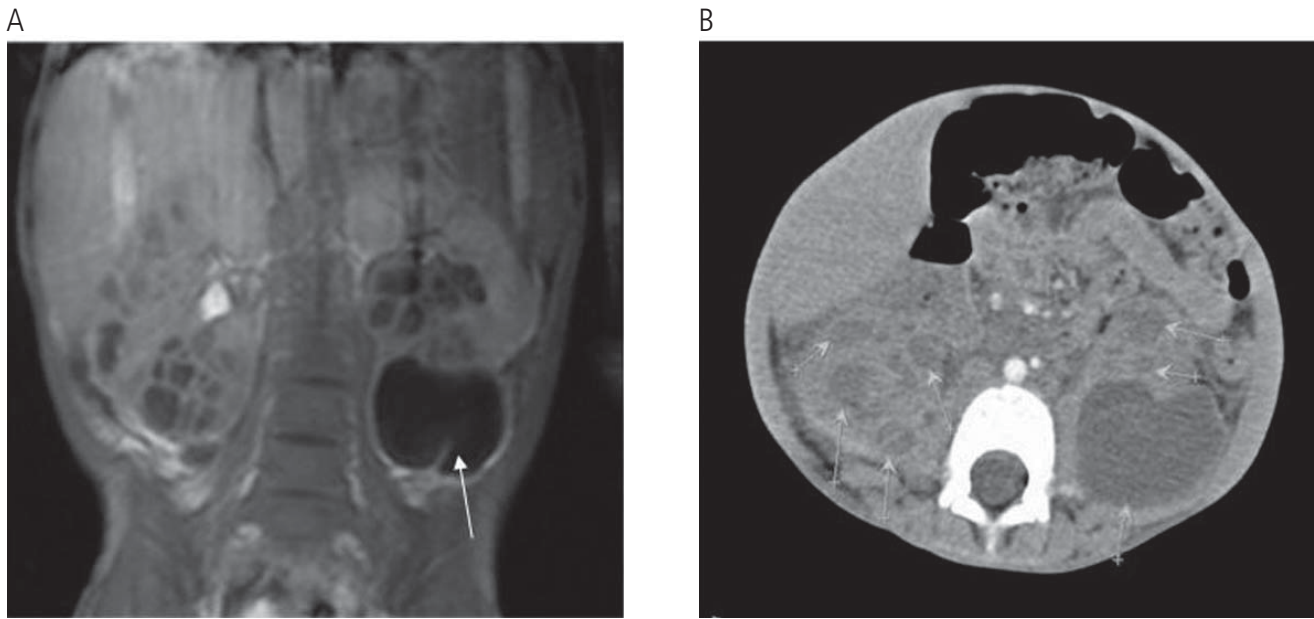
Bilateral multiple renal abscesses. A, T1-weighted magnetic resonance image of the abdomen. B, Computed tomography image of the abdomen.
